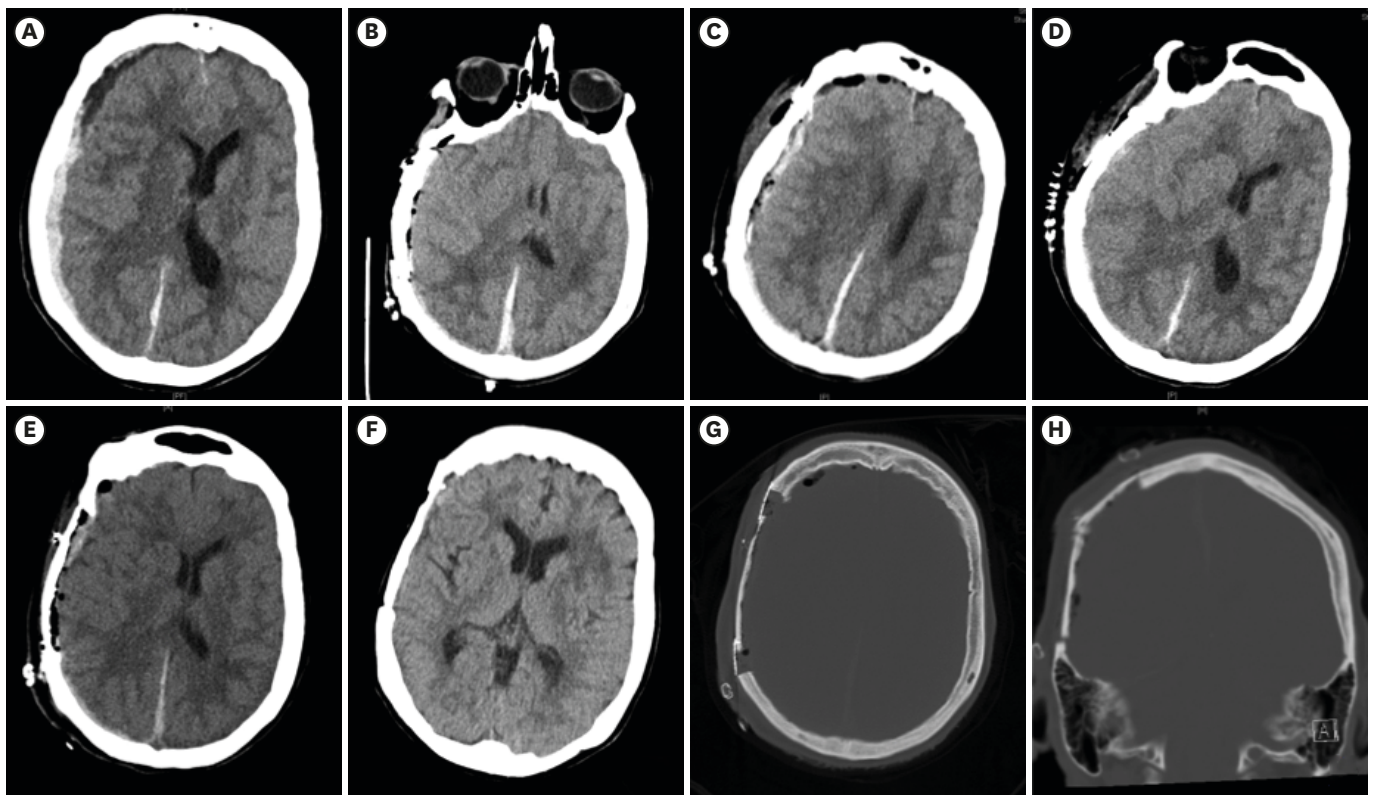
(A) CT on presentation demonstrating 8 mm right-sided acute SDH with 9.6 mm of MLS, (B) post-operative CT with evacuation of SDH and improvement of MLS to 5 mm, (C) mild re-accumulation of right-sided SDH with (D) 9.8 mm MLS on post-operative day 2. (E) Post-operative CT after re-evacuation and split thickness decompression showing immediate and (F) continued expansion on post-operative day 7 of the cerebrum into decompressed area. (G) Axial and (H) coronal bone window CT at 6 months demonstrating the volume of decompression allowed by drilling of the inner cortex. CT: computed tomography, SDH: subdural hematoma, MLS: midline shift.
